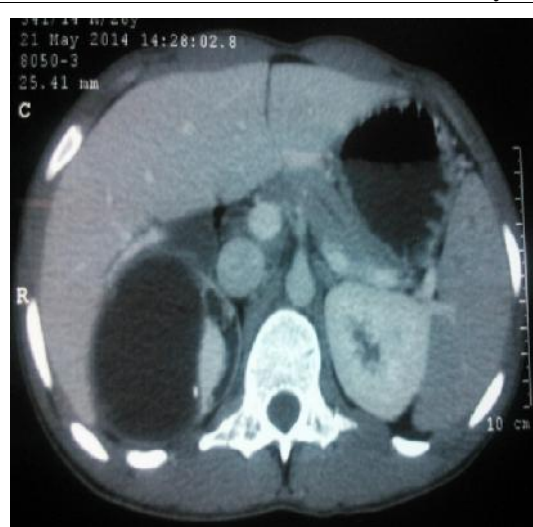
Contrast-enhanced computed tomography scan of the abdomen (case 2) showing sub-capsular hematoma of the right kidney with no active bleeding with eccentric renal parenchyma.
